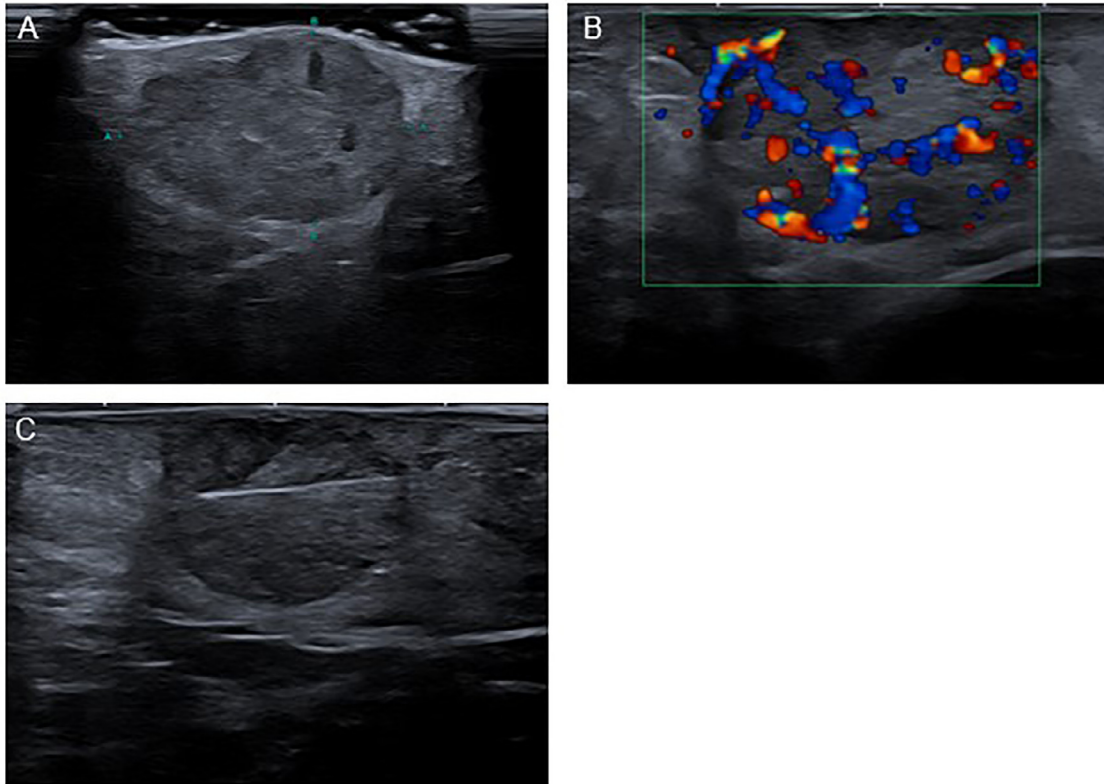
Repeat ultrasound of right axillary lesion after 12 wk. (A) Lobulated heterogenous mass measuring 15 x 21 mm within the subcutaneous tissue extending to the skin. (B) Marked internal vascularity on color Doppler imaging. (C) Ultrasound-guided core biopsy.
